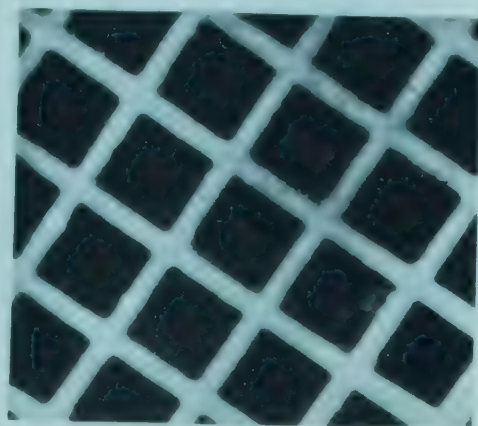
1,500-mesh grid, showing resolution of 1,500-mesh grid by projection micro-radiography.
